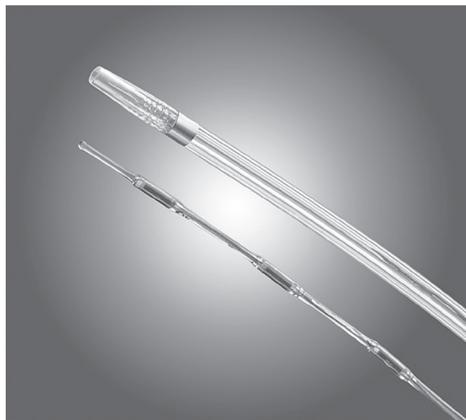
Ultrasound-accelerated thrombolysis catheter (EKOS EndoWave system, EKOS Corporation, Bothell, WA, USA).
